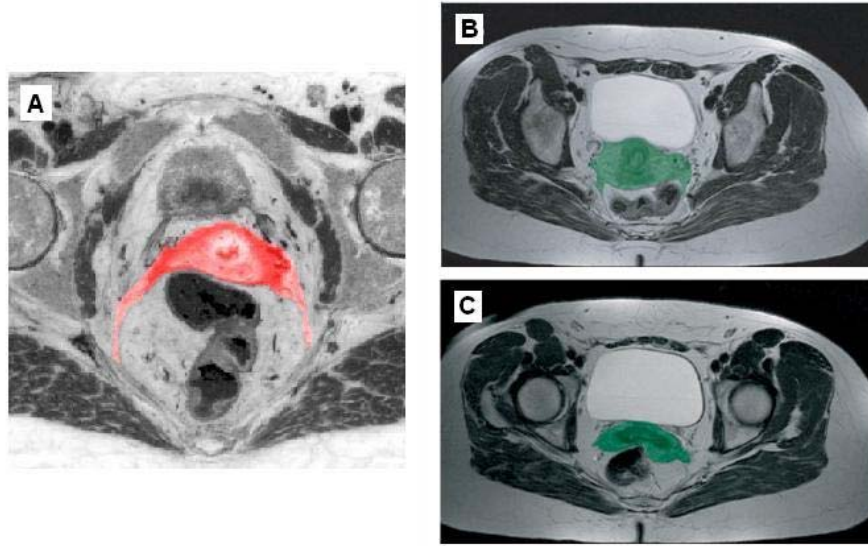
MRI scans with the Müllerian compartment highlighted in red (A) (reprinted from: (8) with permission from Der Pathologe) and green (B,C) (reprinted from: (12) with permission from Elsevier, Lancet Oncology); (A and B) transverse at the level of the cervix and (D) transverse at the level of the proximal vagina
